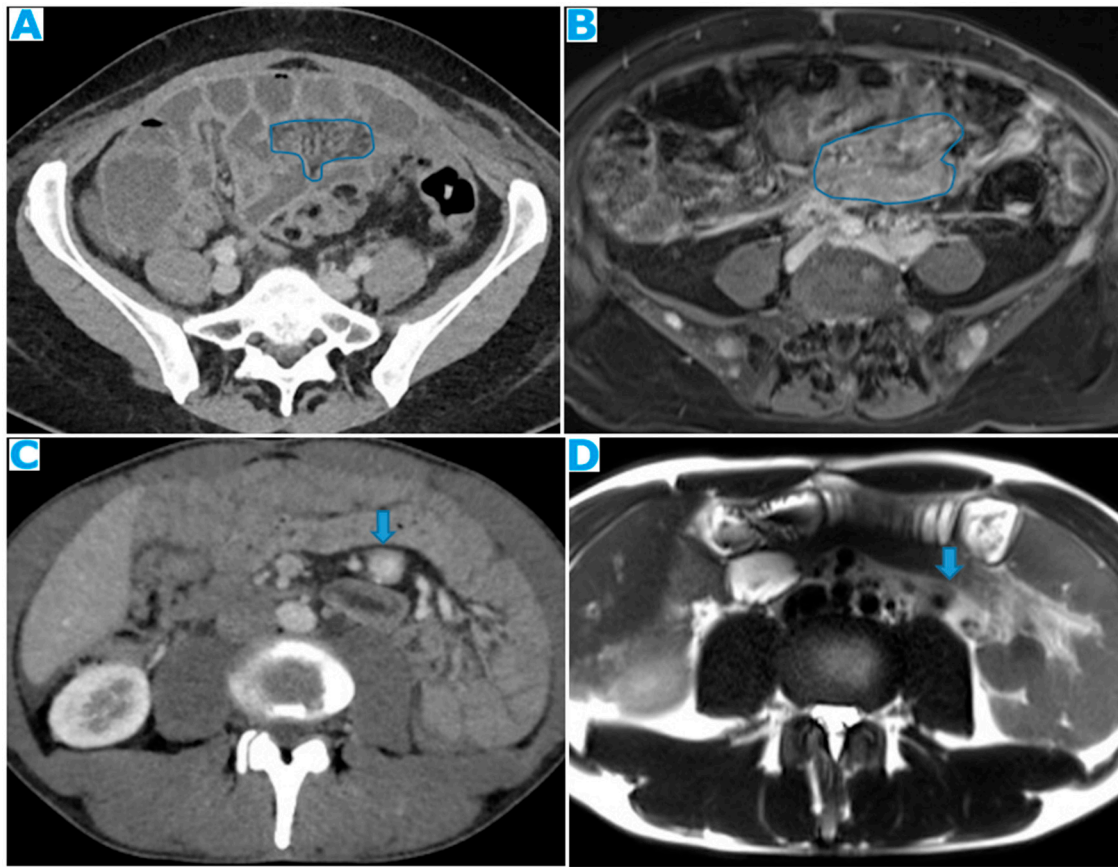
Axial CE-CT (A). PC from stomach adenocarcinoma: Stellate mesentery. Axial CE portal phase FST1WI (B). PC from lobular breast adenocarcinoma: Stellate mesentery, notice the perivascular distribution. Axial CE-CT (C), axial T2WI (D). PC from stomach adenocarcinoma: Isolated perivascular deposit within the mesentery, as a soft tissue mass surrounding a branch of the SMV.
